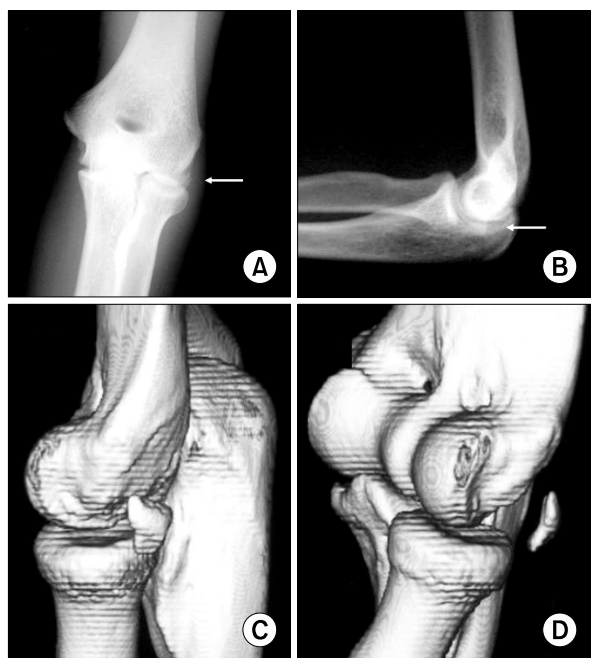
(A, B) The preoperative anteroposterior and lateral simple radiographs show a radio-opaque density around the radio-capitellar joint (white arrow). (C, D) The reconstructed 3-dimensional computed tomographic images reveal a bony fragment on the posterolateral side of the elbow joint.
